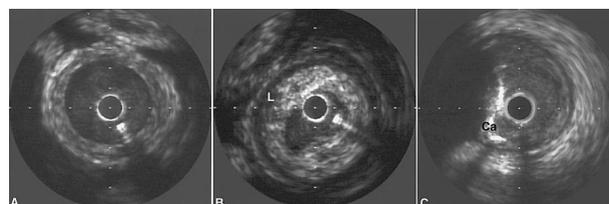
Typical intravascular ultrasound appearances of A, vein graft neointimal hyperplasia; B, concentric, lipid (L)-rich vein graft atheroma; and C, eccentric, calcified (Ca) native coronary artery atheroma. Images courtesy of Dr Khaled M. Ziada and Dr Steven E. Nissen.
